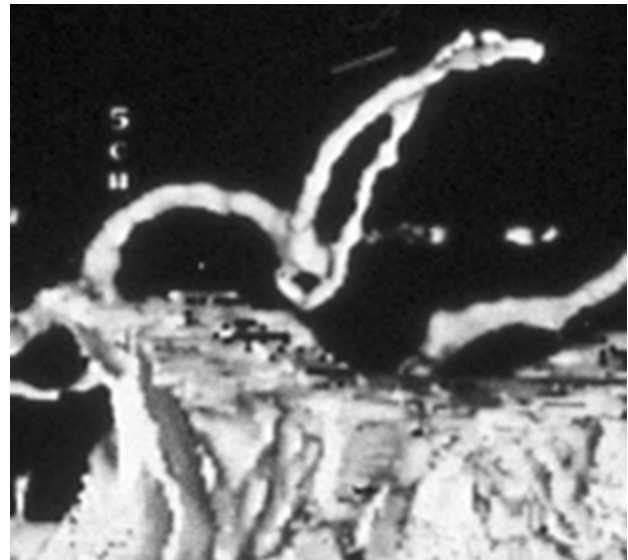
Brain CT angiography 3D reconstruction in SSD (surface shaded display). Aneurysm of the anterior communicating artery (blue arrow).
